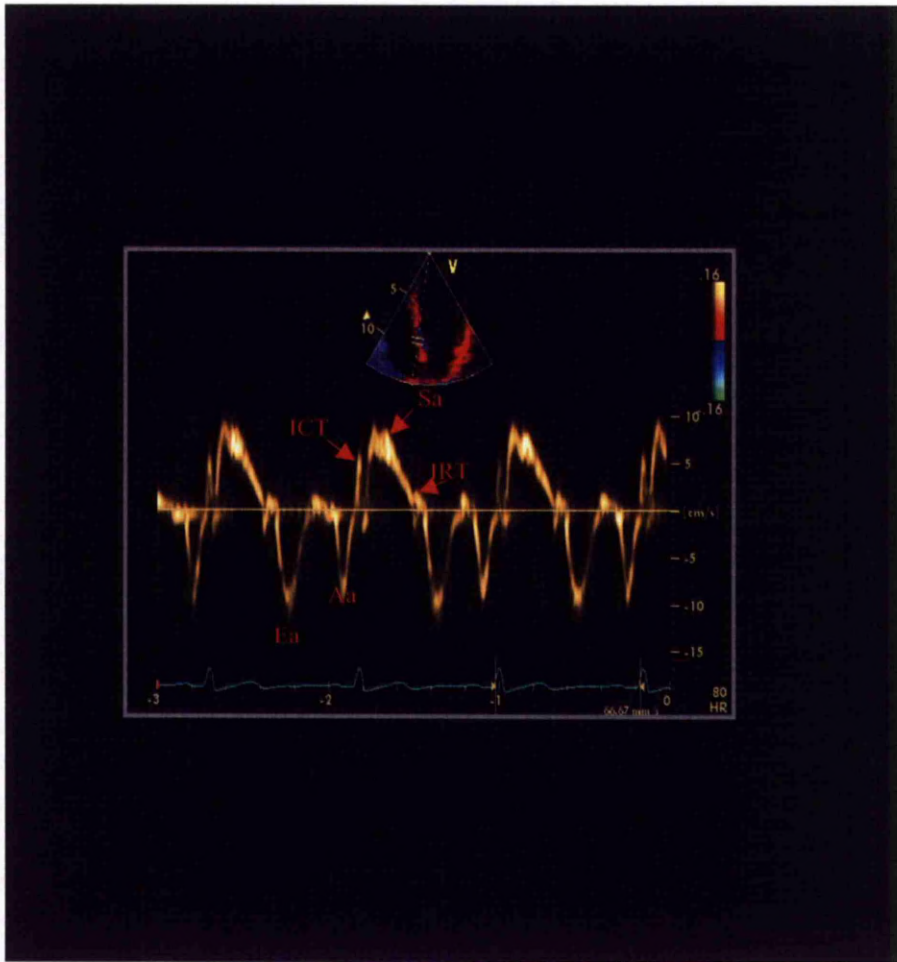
Tissue Doppler velocity curve in a healthy volunteer. Apical 4-chamber view. The pulsed wave Doppler sample volume is positioned in the basal interventricular septum. The initial positive excursion represents the isovolaemic contraction time (ICT), Peak systole (Sa) is followed by a positive excursion represents the isovolaemic contraction time (IRT) followed. The negative waves represent early (Ea) and late (Aa) diastole. (Own image).
